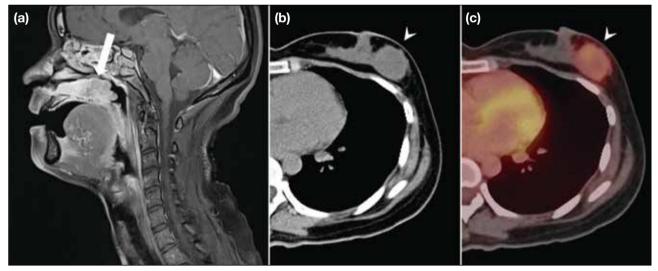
A 29-year-old female with biopsy-proven alveolar rhabdomyosarcoma in the nasopharynx (arrow) as shown on a sagittal post-contrast T1-weighted image (a). (b, c) A staging ¹⁸F-fluorodeoxyglucose positron emission tomography–computed tomography shows a hypermetabolic mass at 3 o'clock position in the left breast (arrowheads). Subsequent biopsy and left mastectomy confirmed a rhabdomyosarcoma metastasis in the left breast.
